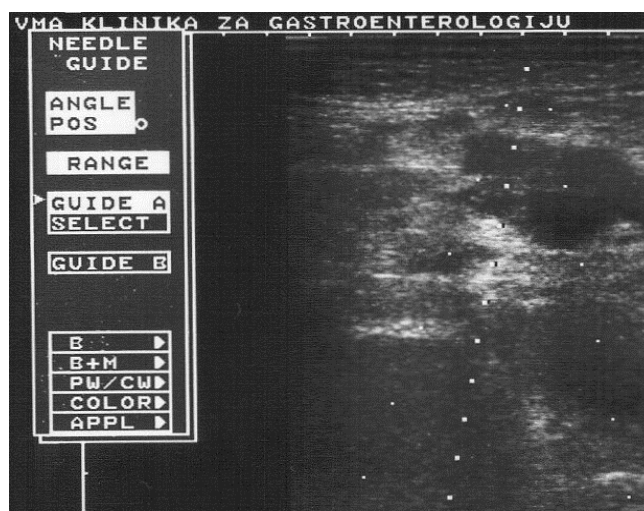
Ultrasound image of guided biopsy of the pancreas.
